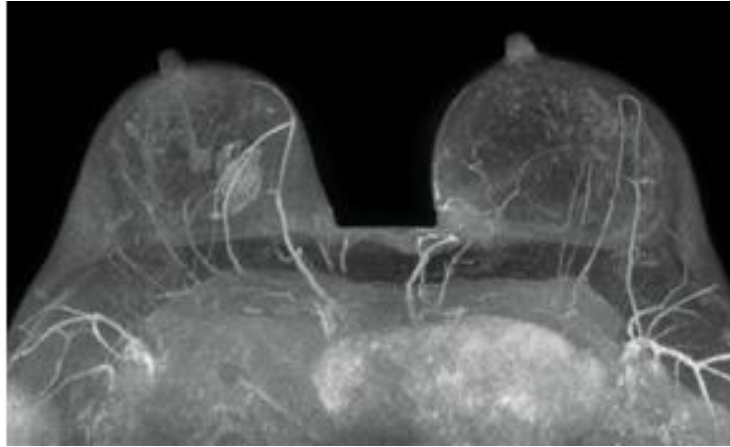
MRI scan of breast. [20]
